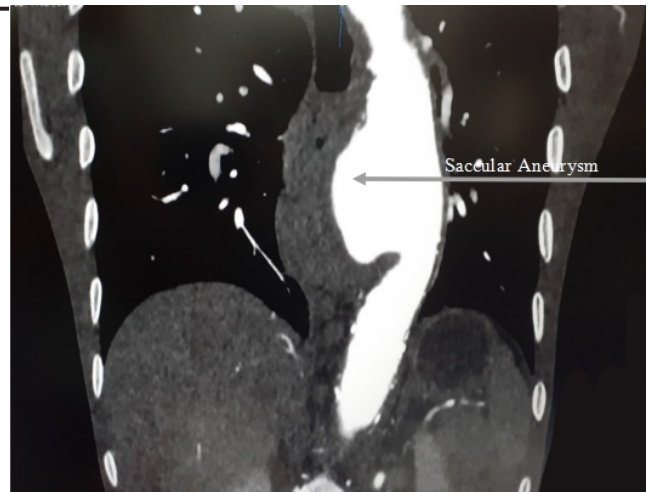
CT chest showing saccular aneurysm
